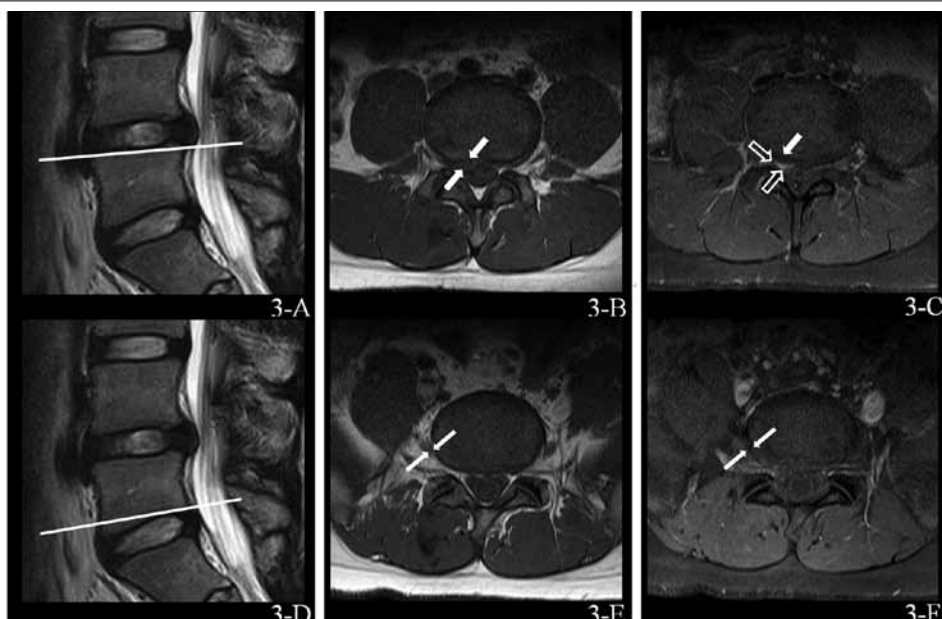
Pre-dorsal root ganglion enhancement in lumbar disc herniation. Contrast-enhanced MRI of a 20-year-old man shows a right paramedian extruded disc herniation with nerve root enhancement (pre-DRG only enhanced). At L5 pre-DRG level (3-A), axial unenhanced T1-weighted (3-B), and contrast-enhanced T1-weight image (3-C) represent prominent L5 pre-DRG enhancement. At L5 post-DRG level (3-D), axial unenhanced T1-weighted (3-E), and contrast-enhanced T1-weight image (3-F) does not show nerve root enhancement.
